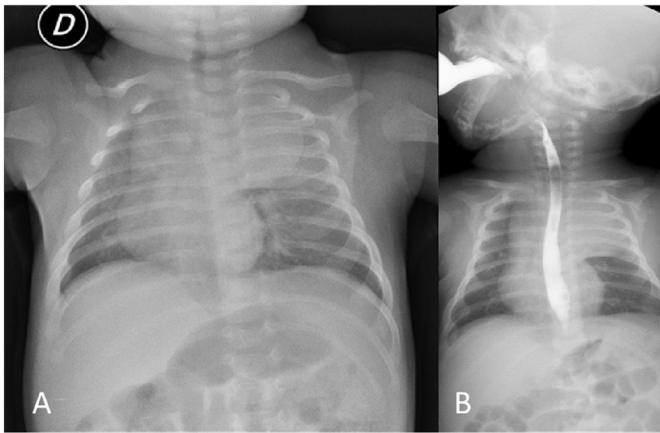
A) Chest radiograph showing the round radio-opaque lesion that occupies the left upper hemithorax with slight shifting of mediastinum toward the contralateral side. B) An upper GI contrast study showing normal esophageal contour with no evidence of communication with the cystic lesion.
